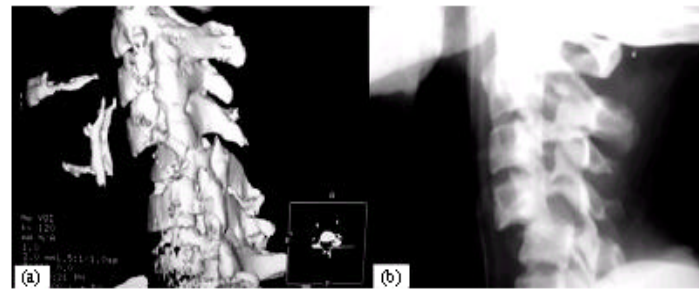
Bilateral facet dislocations of C4-C5. (a) Three-dimensional spiral computed tomography. (b) Lateral cervical plain radiography
